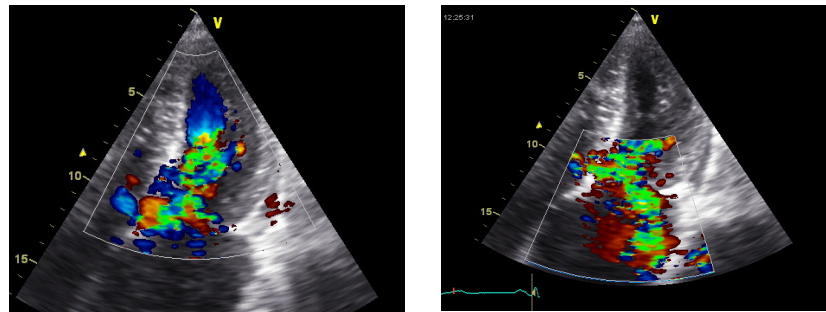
Midventricular and LVOT-obstruction in color Doppler and mitral regurgitation
